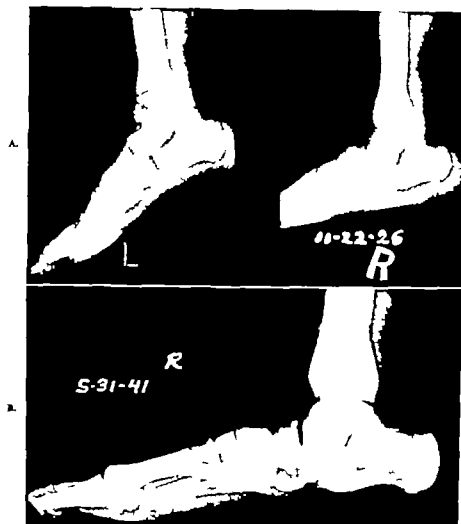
R. V. A, Lateral roentgenograms of both feet of boy 8 years old. There is a unilateral convex pes valgus with the talus in a vertical position, and the navicular bone is articulating with the superior surface of the neck. The calcaneus is plantar flexed. B, The same patient when 23 years old. There is complete luxation of the talonavicular joint, and the navicular bone has become deformed. Although there was a severe rigid flatfoot, the patient was not complaining of any disabling symptoms. No treatment was necessary.
